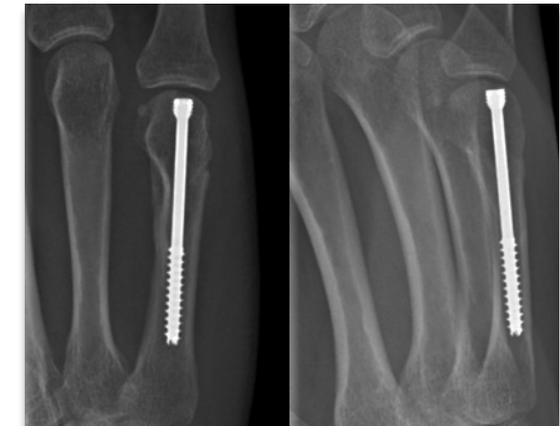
Radiograph demonstrating IMHS fixation of metacarpal fracture.
